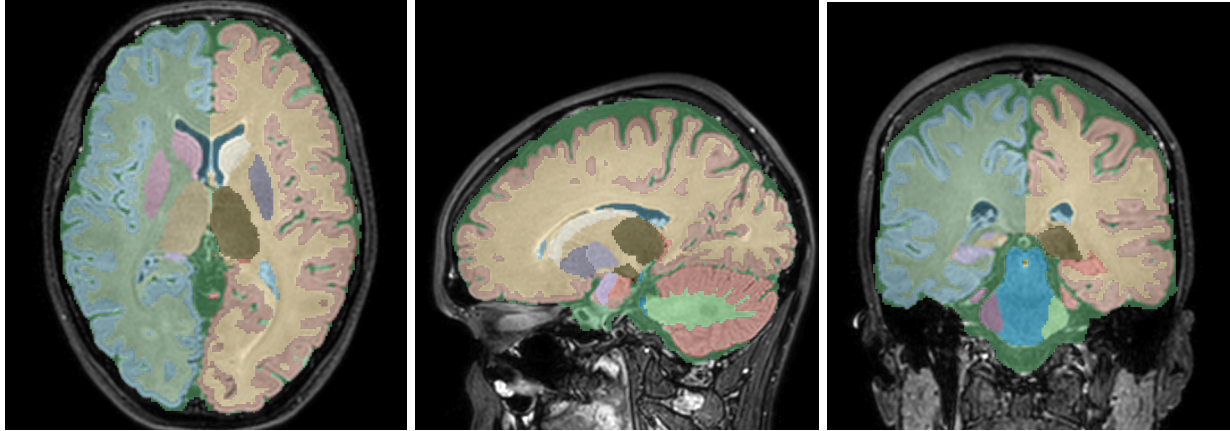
Example brain segmentation of FLAIR sequence using Hetalox segmentation software.
